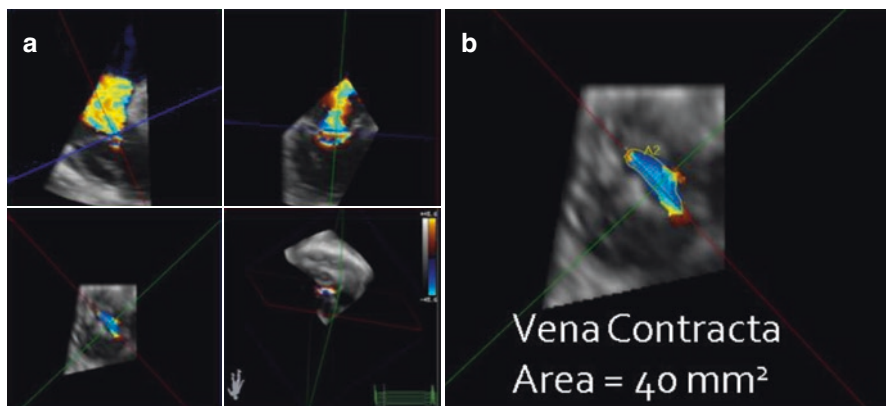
Multi-planar reconstruction of a 3D color Doppler volume. Panel a shows the multiplanar reconstruction of a 3D color Doppler volume, where the *green* and *red* planes are used to align the *blue* plane in the vena contracta of the jet. The vena contracta area is then planimetered in the *blue* plane (panel b)
